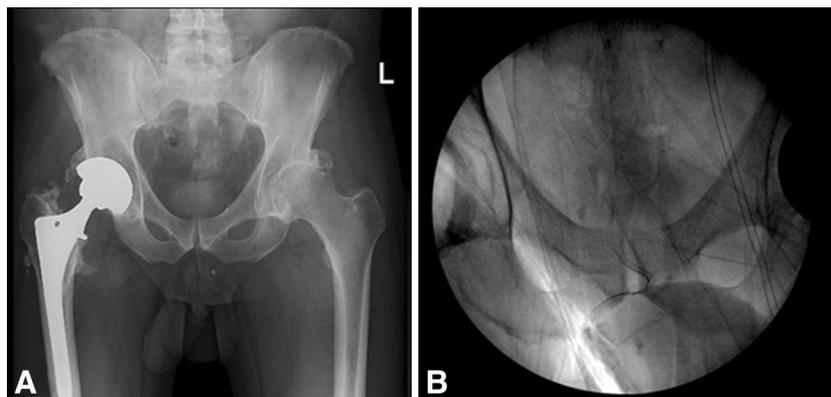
B (A) A preoperative AP radiograph of the pelvis was obtained with the patient supine and shows primary osteoarthritis of the left hip. (B) The fluoroscopic image was obtained with the patient in the lateral position on the operating room table with the C-arm
